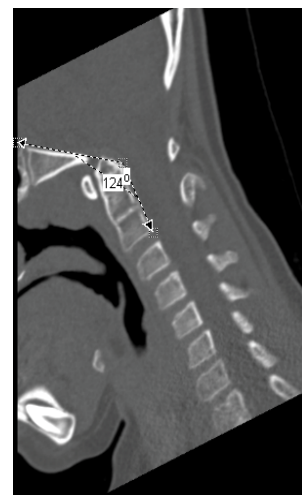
Pre-operative non-contrast CT of the cervical spine demonstrating the acuteness of the clivoaxial angle (125 degrees).
